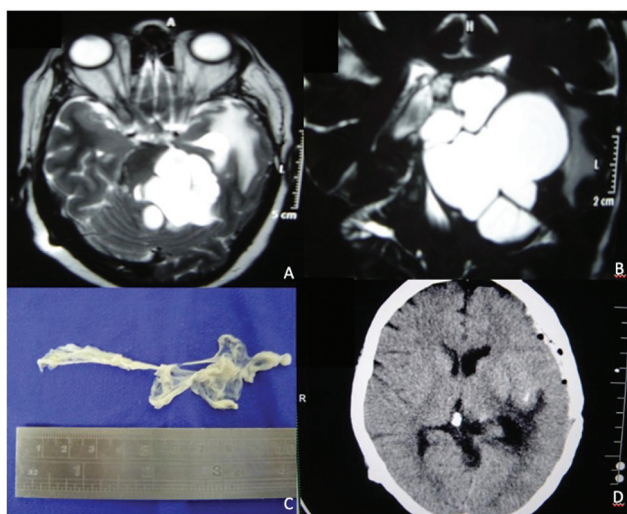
Axial and coronal T2-weighted magnetic resonance imaging revealing a voluminous multiloculated cystic lesion occupying the quadrigeminal cistern (A, B). Resected walls of the cyst (C). Postoperative skull computed tomography showing cyst resection.
